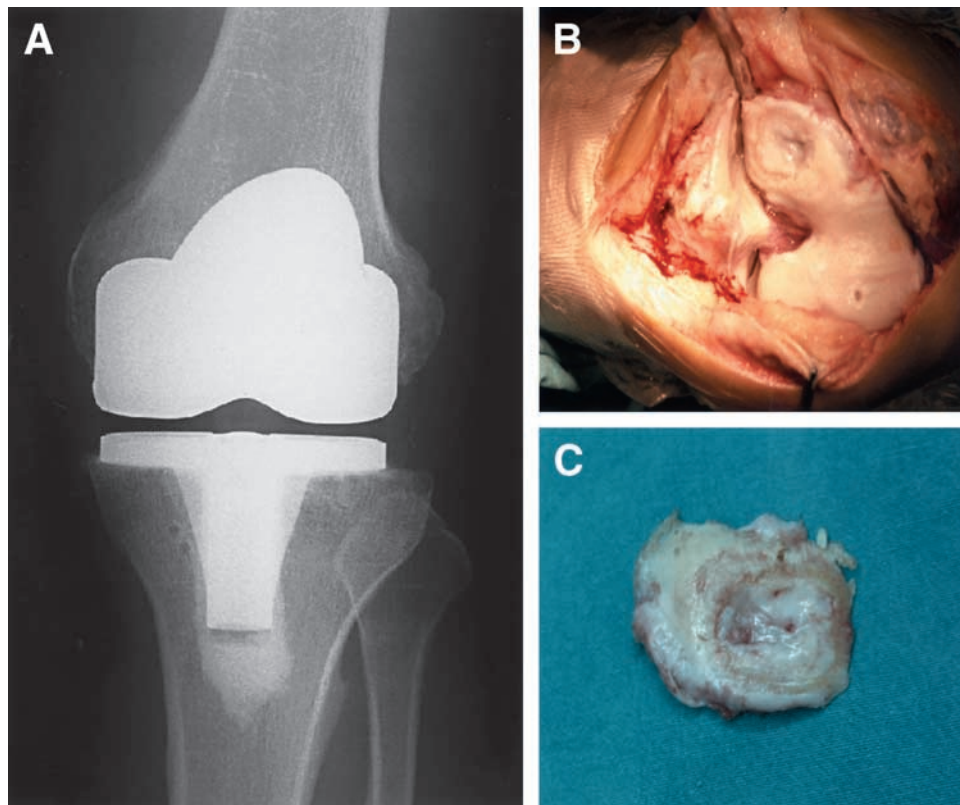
(A) Anteroposterior radiograph of the right knee after a total knee arthroplasty. (B) Operative finding of the femoral condyles. Note the MFC lesion covers most of the weight-bearing part. (C) The resected lesion.
